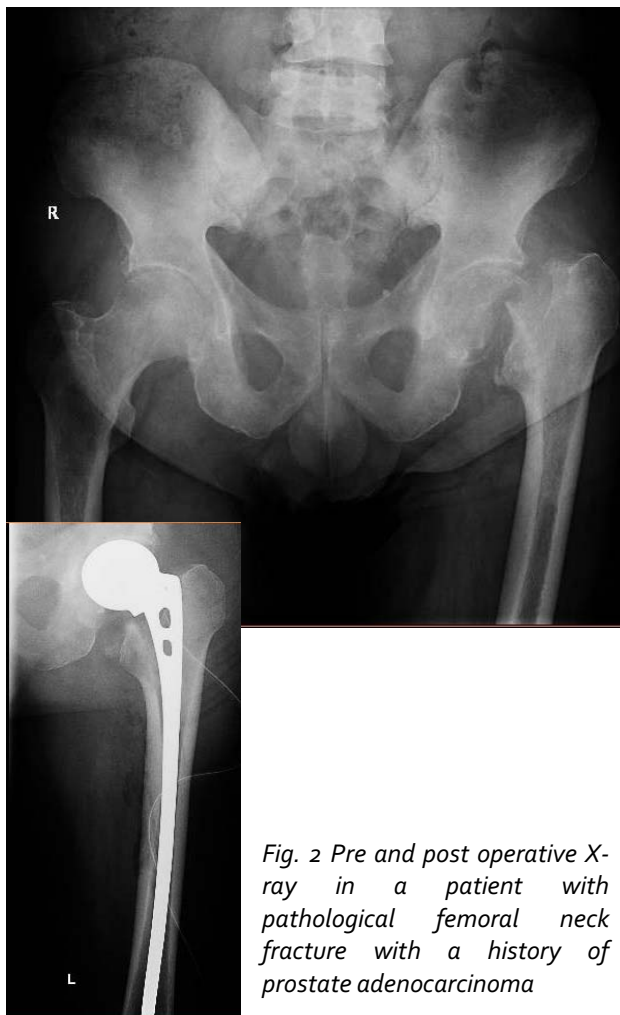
Pre and post operative X-ray in a patient with pathological femoral neck fracture with a history of prostate adenocarcinoma
